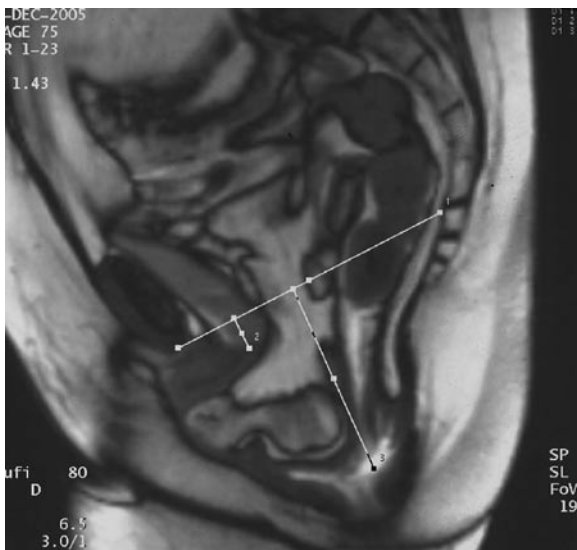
Dynamic MRI. Large enterocele associated with a sigmoidocele. Normal aspect of the anterior compartment
